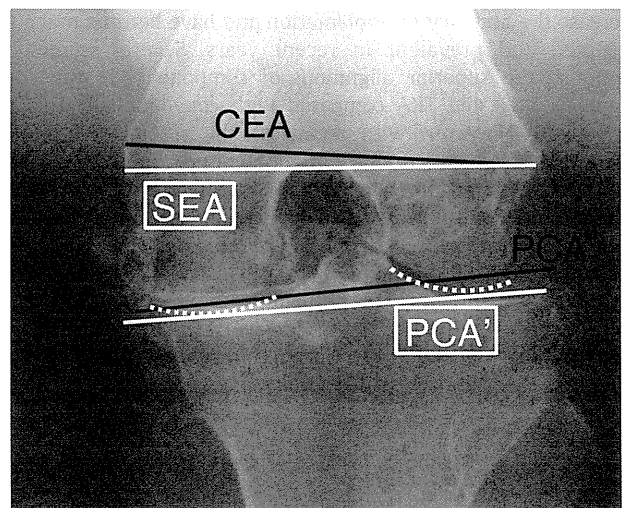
Predicted condylar twist angle (p-CTA). P-CTA is the angle between SEA and PCA'. PCA' is the line connecting the posterior margins of the two dotted curves which are the assumed posterior femoral condyles with the articular cartilage included.
